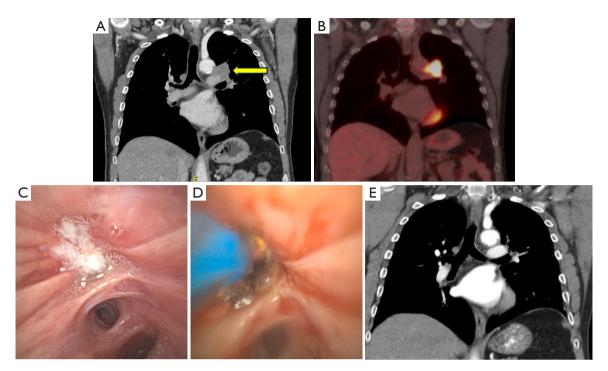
A 57-year-old male with non-small cell lung cancer. (A) Sagittal CT thorax with contrast image with left upper lobe T4N0M0 indicated by yellow arrow. (B) Sagittal fused PET-CT indicating PET avid left upper lobe mass. (C) Endobronchial image using the Ambu® aScopeTM 5 2.8 single use bronchoscope identifying malignant airway obstruction in the anterior segment of the left upper lobe. (D) APC of the left upper lobe tumour using the Ambu® aScopeTM 5 2.8 single use bronchoscope. (E) Sagittal CT thorax with contrast image showing response of the tumour to neoadjuvant chemotherapy and immunotherapy. The patient declined subsequent surgery. CT, computed tomography; PET, positron emission tomography; APC, argon plasma coagulation.
